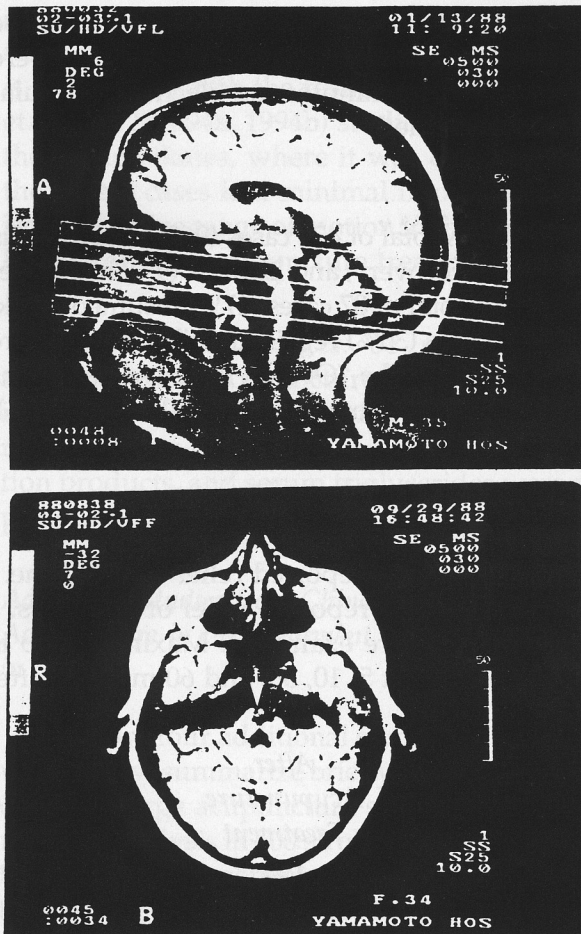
T₁ MRI scan performed at 6 years poststroke, for the patient presented on the previous page.
